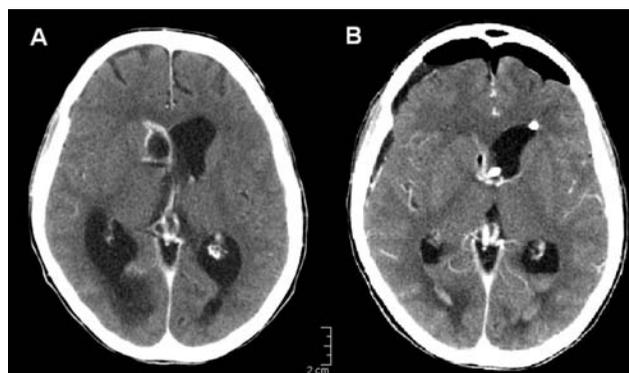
Brain abscess caused by *Scedosporium apiospermum* (patient 2). A) Images from contrast-enhanced computed tomographic scan show a ring-enhancing lesion in the head of the nucleus caudatus (2 × 1.5 cm) bulging in the right lateral ventricle with concomitant resorptive hydrocephalus. B) Control computed tomographic scan after surgical drainage and placement of ventricular-peritoneal drainage.
